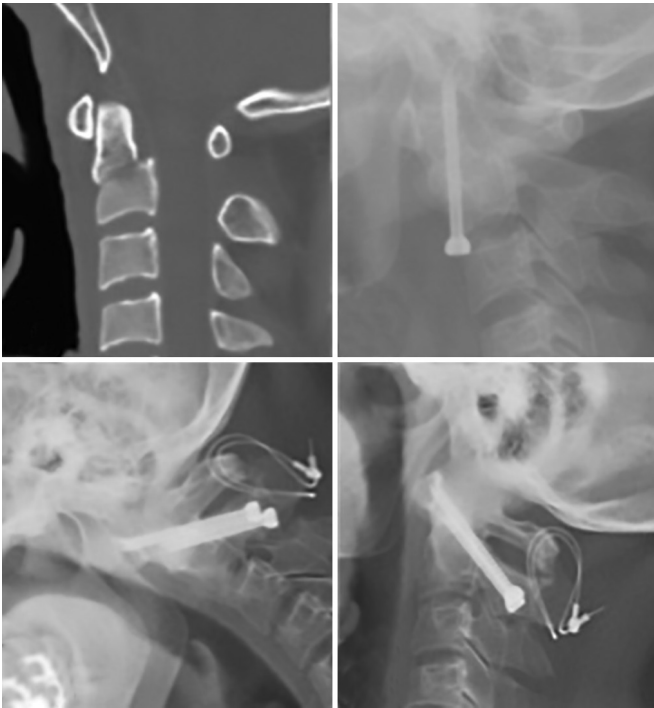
28-year old male with a Type III odontoid fracture as shown on the sagittal CT images (a). This patient underwent an anterior odontoid screw placement. Third postoperative day lateral radiograph (b) showing cut-out of the odontoid screw from the C2 body. This patient then underwent removal of the odontoid screw followed by a C1-2 transarticular screw fixation. One year follow-up radiographs do not show any instability on flexion (c) and extension (d) images.
